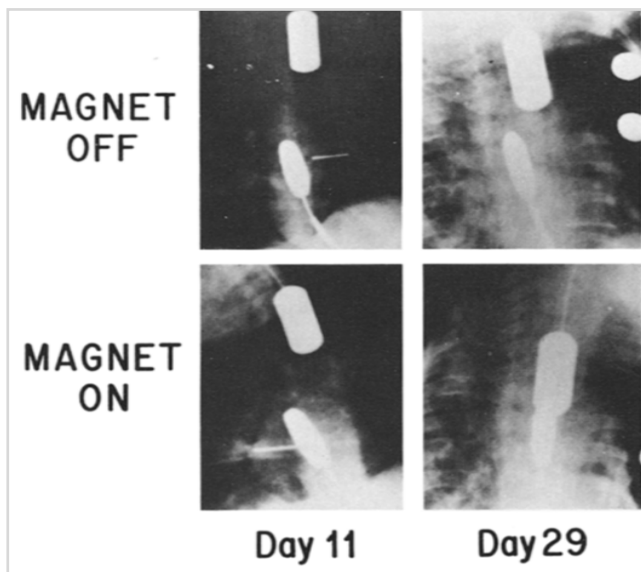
[123] : Roentgenograms on two occasions are shown with the magnet off and on.
